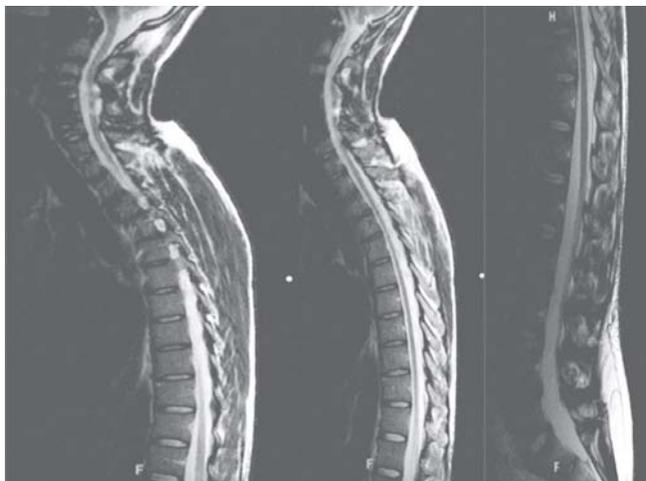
MRI of the Cervical, Thoracic and Lumbar Spine with Gadolinium Contrast Showing Chronic Changes due to C4-5, C5-6 Fusion after Old Cervical Spine Injury without New Pathology like Post-traumatic Syringomyelia, Cord Tethering, or Cord Compression Secondary to Infection, Tumor, or Disc Herniation
